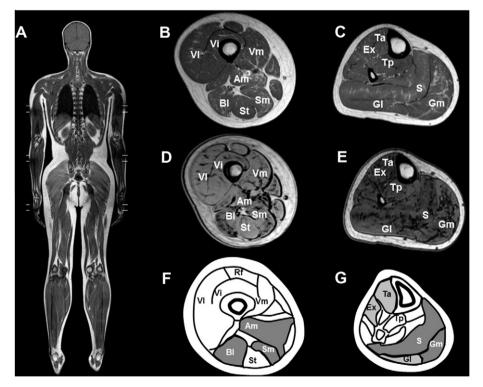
(A) Coronal T1-weighted slices showed prominent fatty degeneration in gluteal muscles, posterior thigh and posterior leg muscles with sparing of upper girdle muscles. (B) At thigh level, MRI showed predominant involvement of the posterior compartment with marked fatty infiltration of adductor magnus (Am), semimembranous (Sm) and biceps femoris long head (Bl). Quadriceps muscles (Rf, VI, Vi, Vm) and semitendineous (St) appear to be spared. (C) At lower leg level moderate fatty infiltration of medial gastrocnemius (Gm) and soleus (S) in the posterior compartment was evident with hypotrophy of lateral gastrocnemius (Gl). Mild hyperintense signal changes were present in anterior compartment muscles, tibialis anterior (Ta) and extensor longus digitorum and hallucis (Ex) with sparing of tibialis posterior (Tp). (D and E) Using out-of phase imaging, at thigh and leg level fatty degeneration is reflected by loss of signal intensity in the same muscles. In anterior compartment of the leg, more evident abnormalities in anterior compartment (Ta, Ex), compared to T1 sequences, were present. (F and G) Patterns of muscle involvement in neutral lipid storage disease with myopathy (NLSDM), based on the literature data and our experience. The replacement of muscle tissue by fat is reflected by the dark gray color of the muscle. Initial and/or variable involvement of the muscle is represented by the light gray color. The white color means spared muscles.
